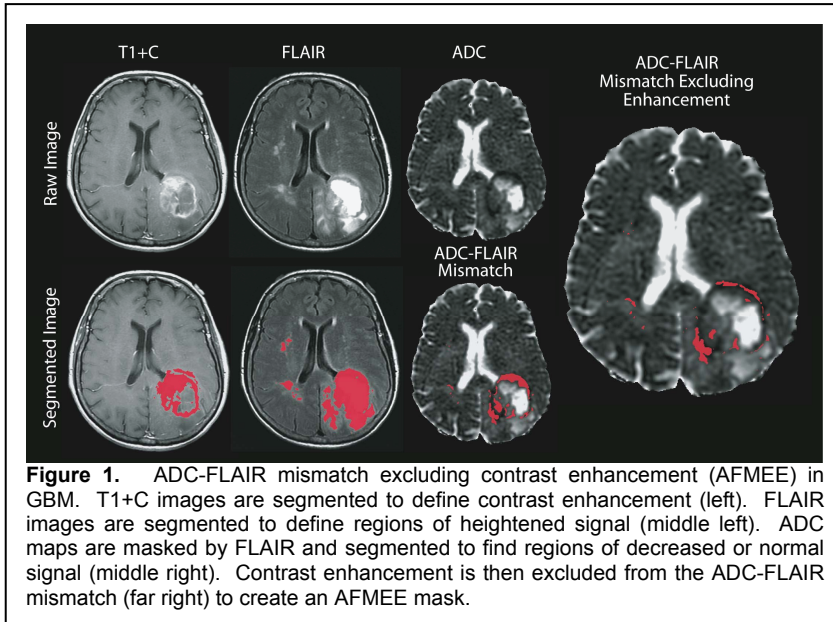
ADC-FLAIR mismatch excluding contrast enhancement (AFMEE) in GBM. T1+C images are segmented to define contrast enhancement (left). FLAIR images are segmented to define regions of heightened signal (middle left). ADC maps are masked by FLAIR and segmented to find regions of decreased or normal signal (middle right). Contrast enhancement is then excluded from the ADC-FLAIR mismatch (far right) to create an AFMEE mask.
